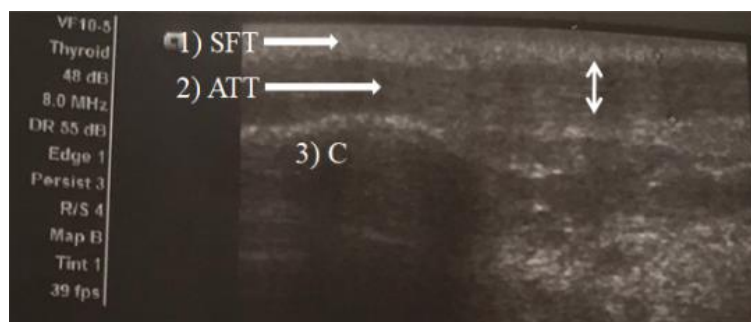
1) SFT (Subcutaneous fat tissue), 2) ATT (Achilles tendon), 3) C (Calcaneus), tendon thickness was measured from longitudinal sonograms of the AT with the aid of a grayscale profile and, 30-mm proximal to the superior aspect of the calcaneus
